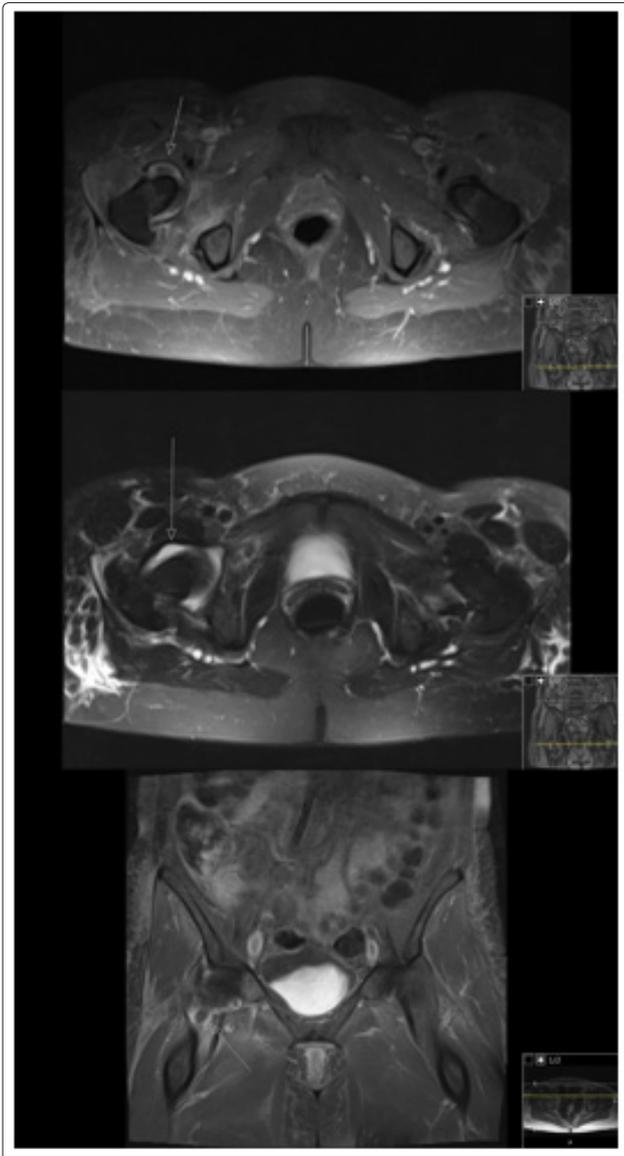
MRI axial and frontal views of the pelvis showing bilateral diffuse soft tissue edema along with anterior compartment myositis, with the right side more severely affected.
